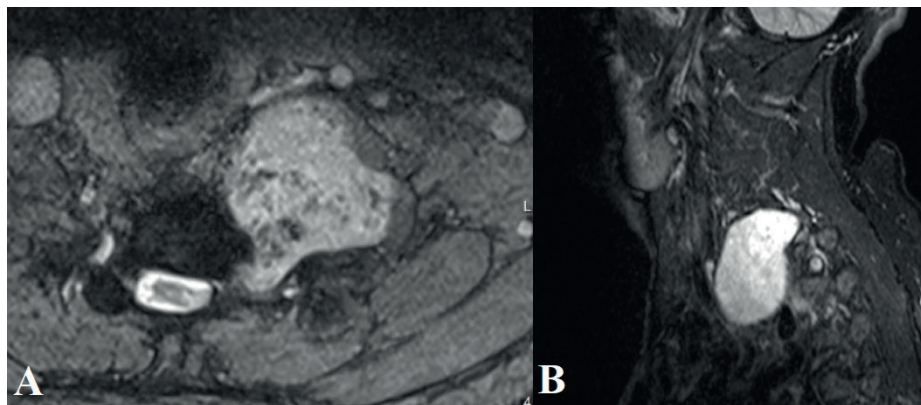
Magnetic resonance imaging of a mass. A. Axial section B. Sagittal section
